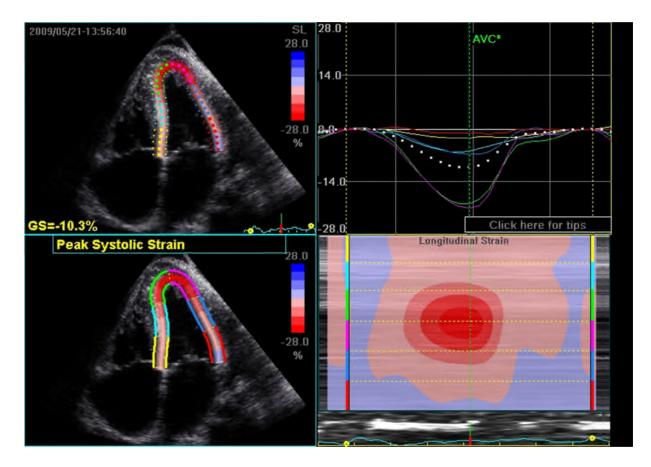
Transthoracic echocardiogram with speckle tracking.
